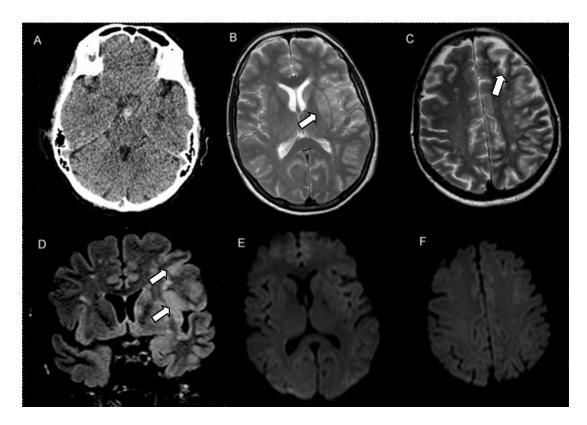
A rare complication of cerebral angiography as a result of possible contrast toxicity. A female patient presented with a small pre-pontine haemorrhage (A). Shortly after cerebral angiography she developed a right hemiparesis with subsequent coma. Repeat angiography was normal. MRI performed within 3 hours showed minimal changes but a second MRI performed at 24 hours showed widespread, predominantly left hemisphere cortical and basal ganglia hyperintesity on T2-weighted and FLAIR sequences (B, C and D, arrows). No diffusion restriction was evident suggesting that this was not a thrombo-embolic process (E, F). The patient made a full recovery after supportive care.
